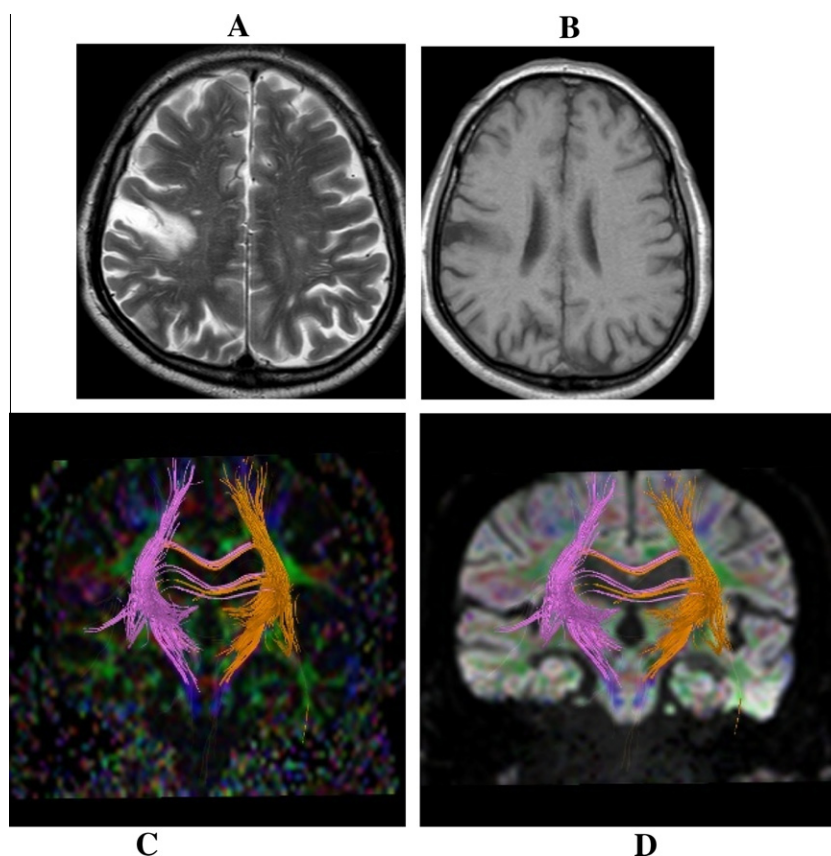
Patient # 13 admitted with left sided heaviness. (A) The T2 weighted image of a patient with subacute ischemic infarction showed a right sided parietal subcortical hyperintense area which is seen as hypointense area on the T1 weighted image. (C and D) The axial directional colored image and the coronal tractography colored image based on DWI show intact pyramidal tracts as they are of the same caliber on both sides. The patient had good outcome on discharge.
